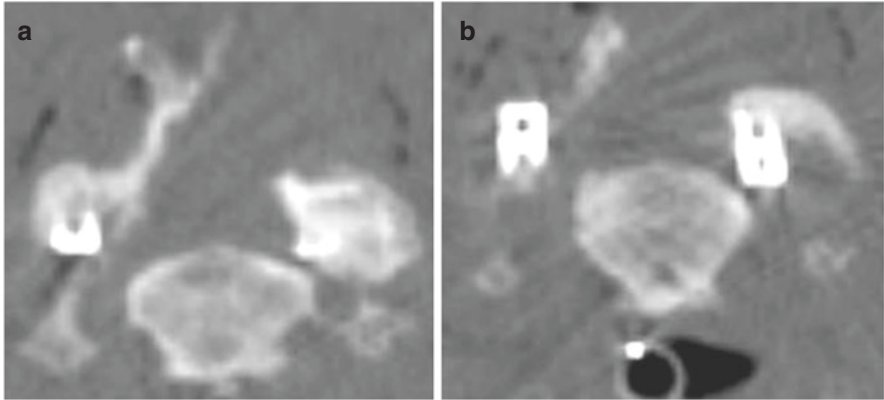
Intraoperative CT demonstrates bilateral cervical decompression through the unilateral approach with good decompression and facet cages in adequate position. (a, b) show different planes of the intraoperative image
